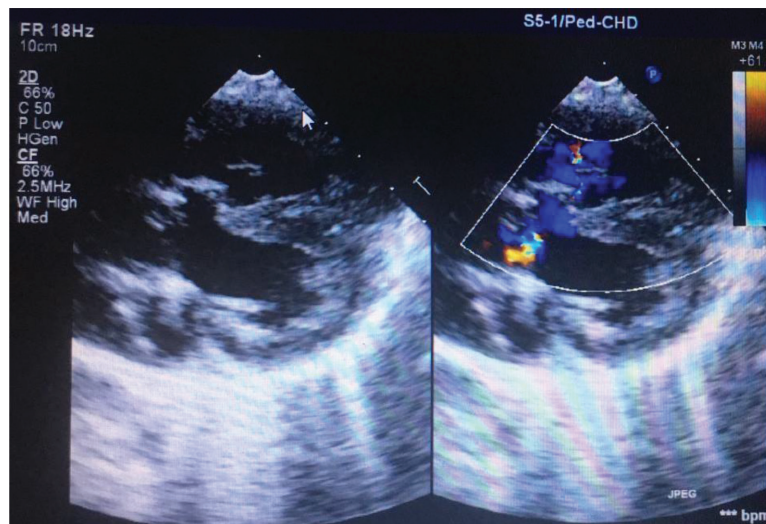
Echocardiography: Perimembranous VSD with aneurysmal tricuspid valve tissue.
